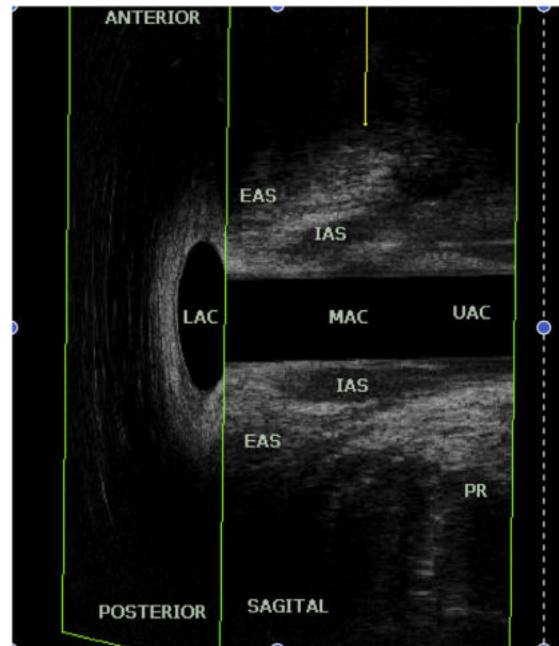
Endoanal tridimensional ultrasound showing the low, mid and upper anal canal in sagittal view, with internal anal sphincter (IAS), external anal sphincter (EAS) and puborectalis (PR).
